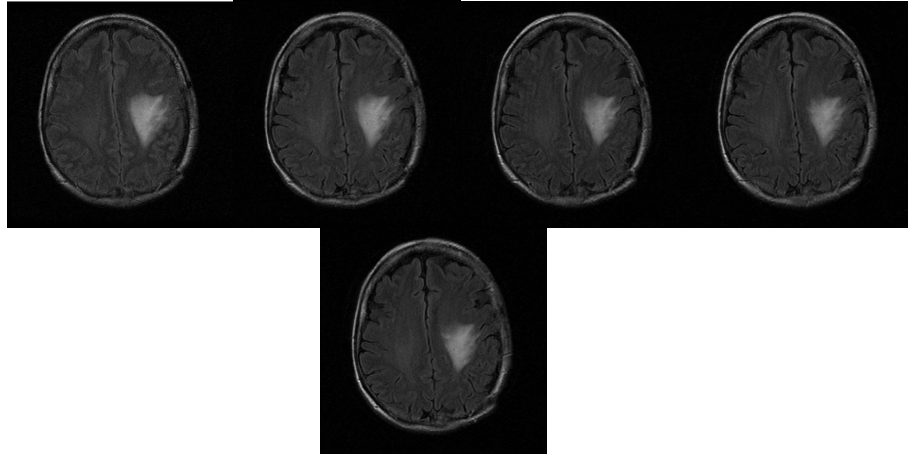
The examples of five MRI examinations of Patient 1 (FLAIR images) (from top to bottom, from left to right corresponding to the first to the fifth period).
